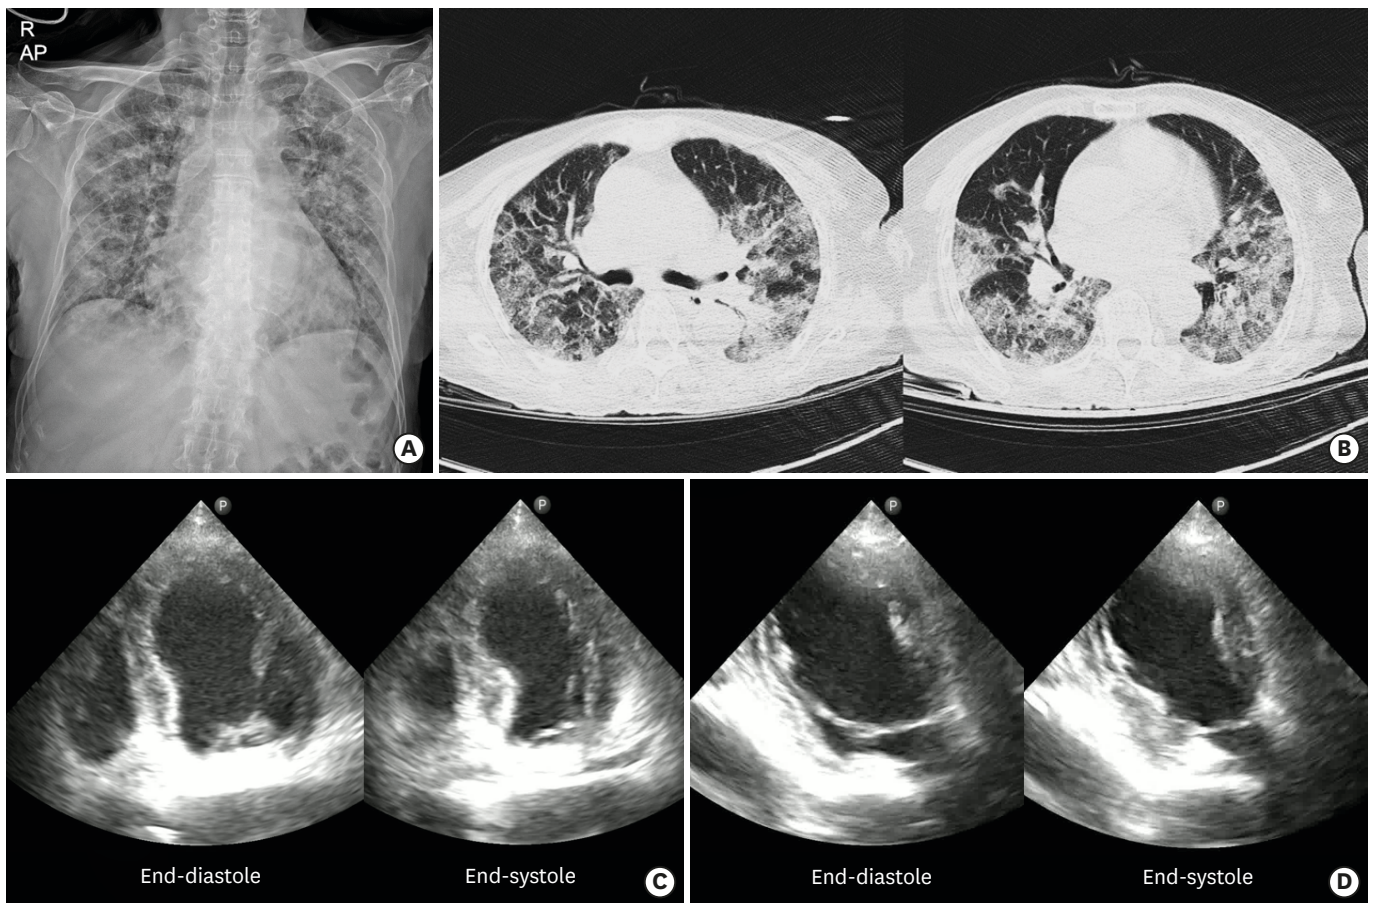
The initial chest X-ray demonstrates the typical diffuse ground-glass appearance that suggests viral pneumonia (A), and the computerized tomographic examinations show diffuse infiltration of bilateral lung fields (B). The echocardiographic examination reveals apical ballooning with dyskinetic movement and severe left ventricular systolic dysfunction (C: apical 4 chamber view, and D: apical 2 chamber view; Movie 2).
